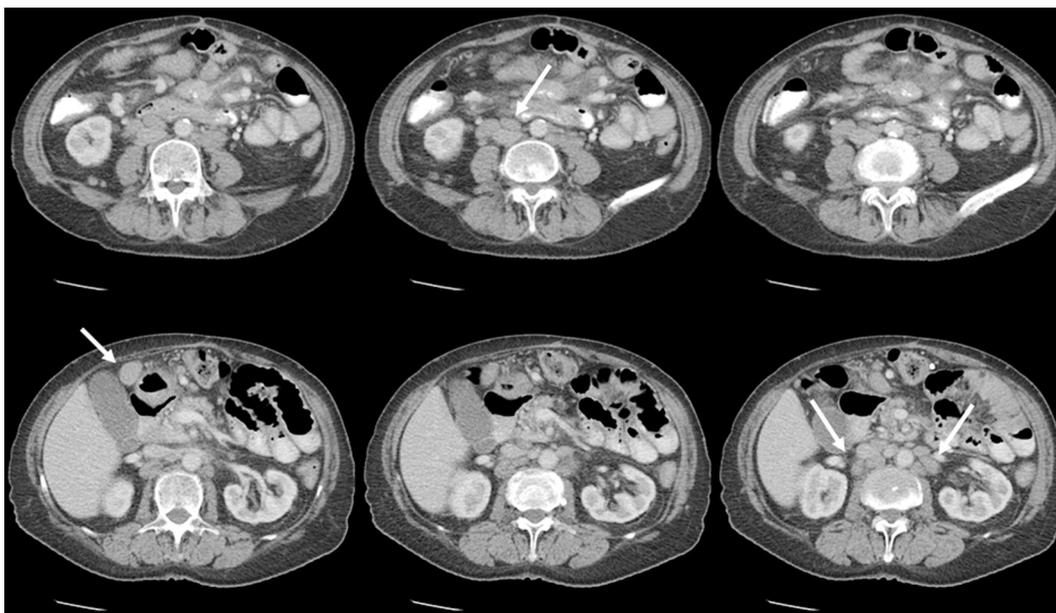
Contrast enhanced CT images showed mesenteric, peri-pancreatic, paraaortic and paracaval lymph nodes (white arrows).
